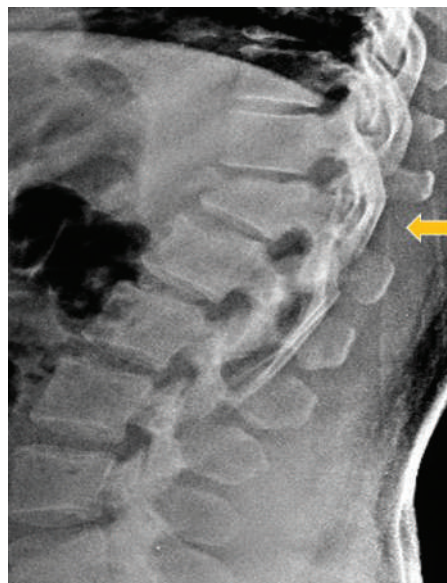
Orthostatic simple, plain radiograph.
